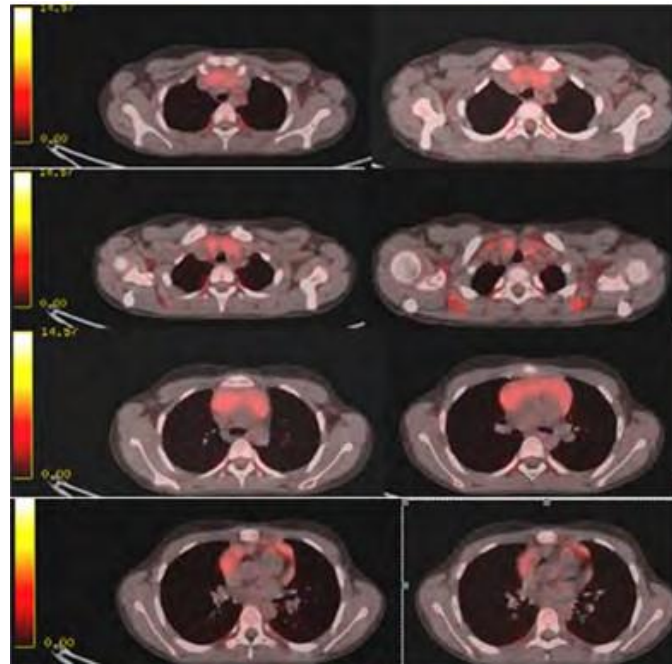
18F-FDGPET/CTfromJanuary2023-Persistenceoftheretrosternalformationinthe frontmediastinum,whichnowpresentsmoreformu- lated, with lobulated contours and a homogeneous metabolic activity SUV max 3.3 .
